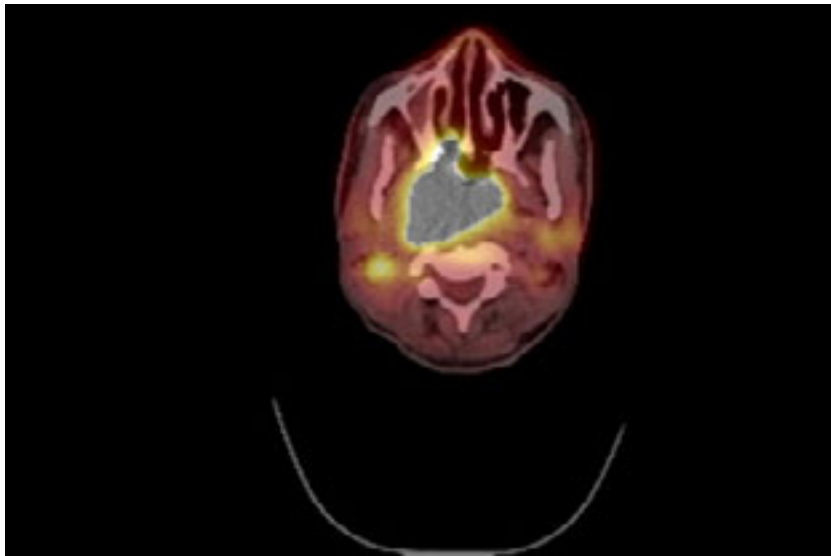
PET/CT scan. Image showing FDG avid right sided nasopharyngeal tumor. A right level V FDG avid lymph node is also noted.
